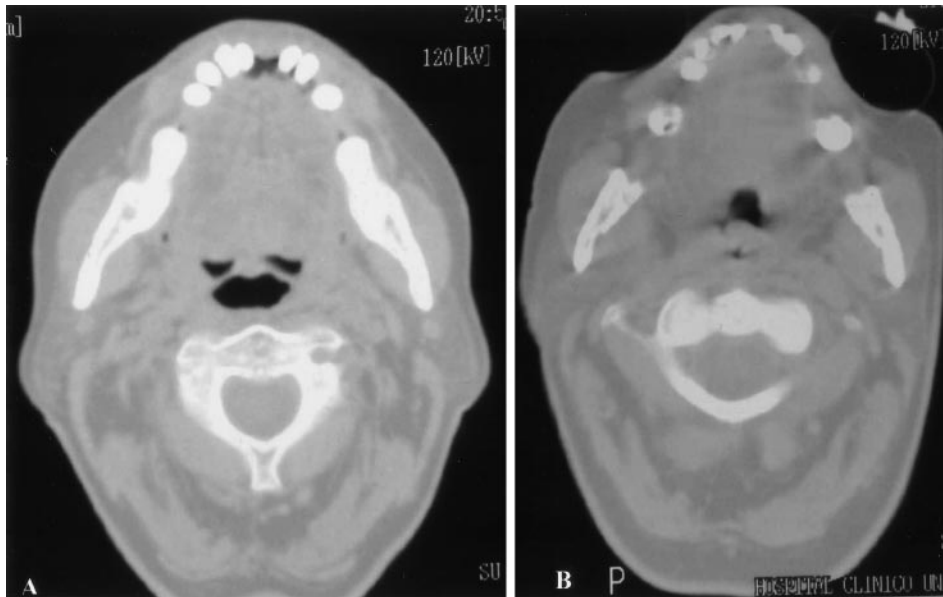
Oropharynx CT scan of a bulbar ALS patient with PCFMI-E < 2.7 L/s. *Left, A:* baseline. *Right, B:* during the exsufflation cycle.
